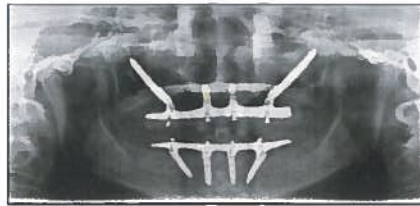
Orthopantomography after 1 year of an All-on-4 hybrid (Nobel Biocare AB) rehabilitation in the maxilla with 2 conventional implants inserted in the anterior area and 2 posterior zygomatic implants inserted through the extramaxillary surgical technique.
